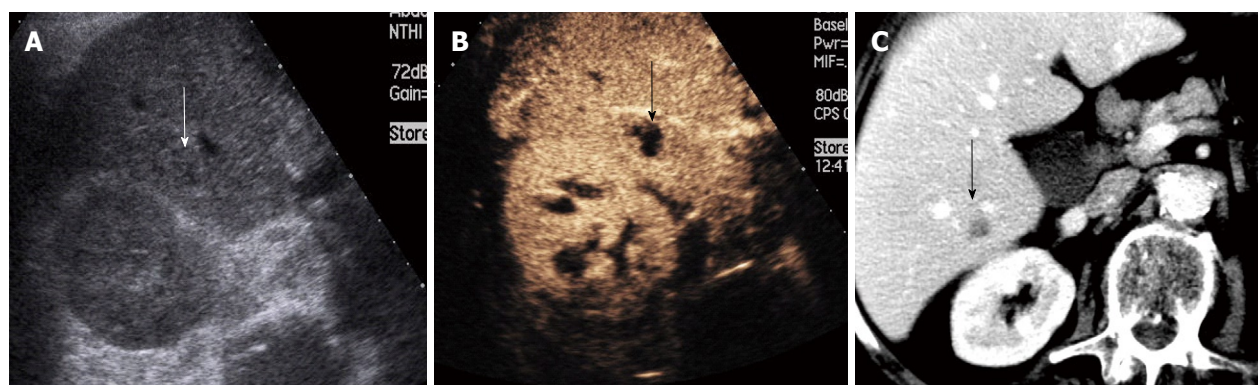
US, CEUS and CT visualizations of the same liver metastasis (indicated by an arrow). The lesion is not recognizable using US, but is visible by CEUS and CT. A: US; B: CEUS; C: CT.
